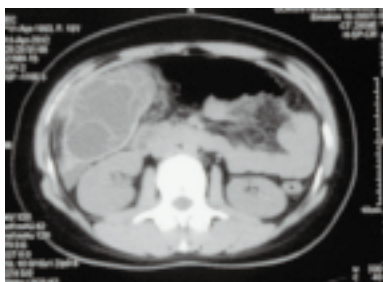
A giant cyst on the right lobe of the liver and irregular appearance due to perforation of cyst wall on the CT examination.
